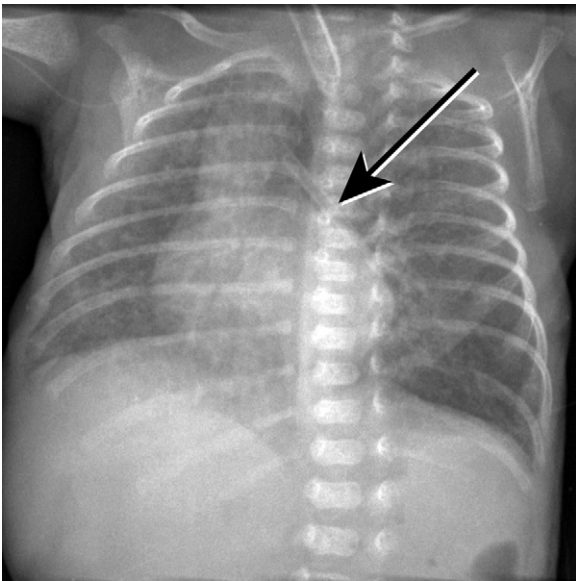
AP chest radiograph showing FB (SCF) in left main bronchus (LMB).
